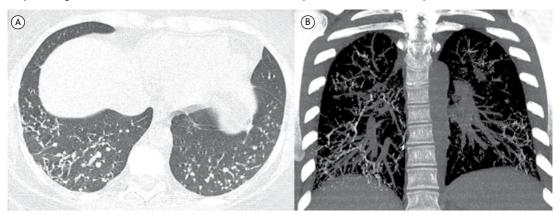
In A, unenhanced axial chest CT scan with lung window settings, showing reticular opacities in the lower lobes of the lungs. In B, coronal reconstruction with bone window settings and maximum intensity projection, showing interstitial calcifications arranged in a branching network pattern.
